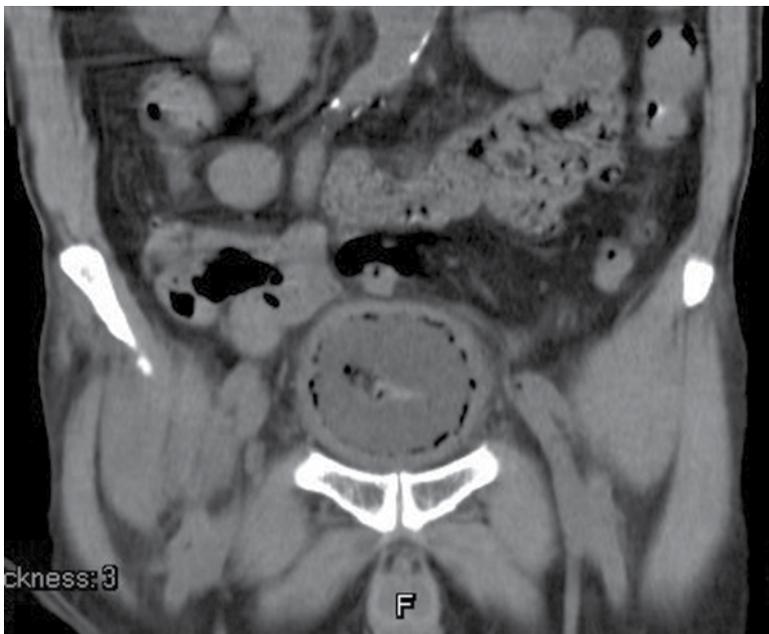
Coronal view of a CT scan showing air in the whole area of the urinary bladder wall with fat standing around this organ.
